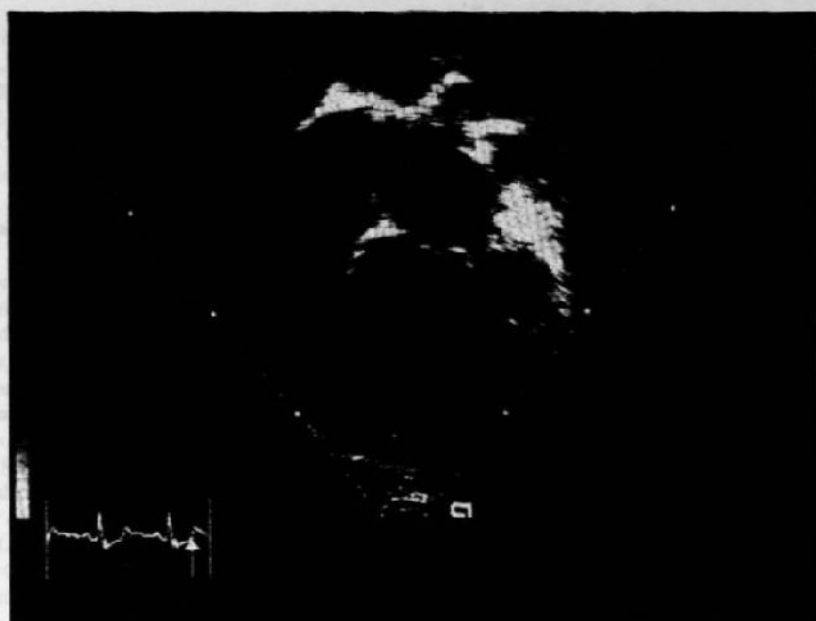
Two-dimensional echocardiogram of a child with dilated cardiomyopathy. Note the large, dilated left ventricle with bulging of the interventricular septum into the right ventricular chamber. In real-time, the left ventricular function is severely depressed.
